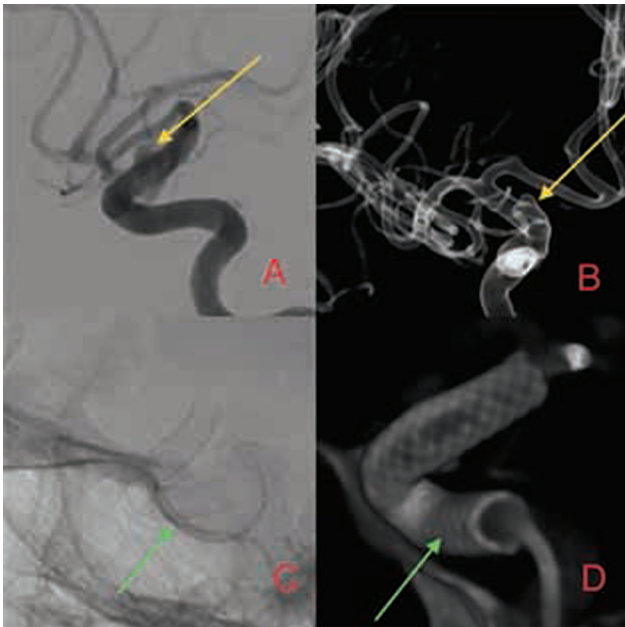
(A) Lateral angiogram. (B) Three-dimensional rotational angiogram of right internal carotid artery (ICA). Yellow arrow in parts (A) and (B) denotes blister aneurysm in supraclinoid segment of right ICA. (C) Single shot image of flow-diverting device Vaso computed tomography. Green arrow denotes deployed flow diverter with full coverage of the aneurysm neck.
